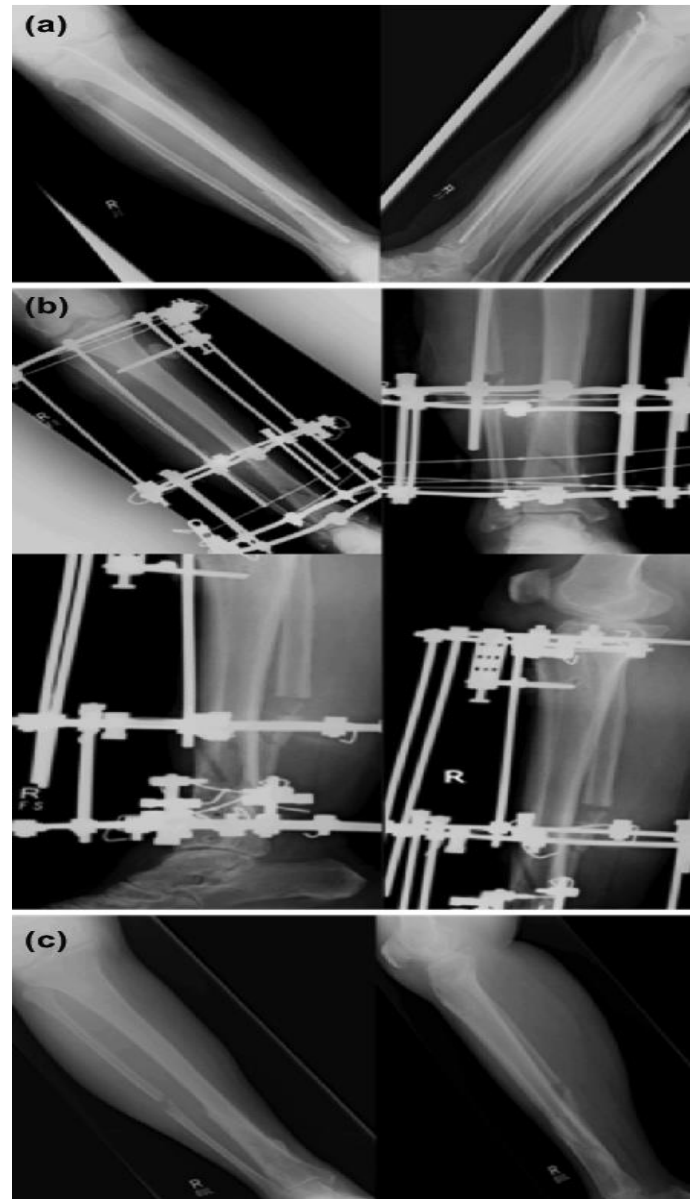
Patient 2's radiographs. (a) Anteroposterior and lateral images of the tibia before surgery demonstrate tibia nonunion. (b) Anteroposterior and side (bottom row) views following Ilizarov application. (c) Final follow-up: Anteroposterior and lateral images demonstrating bony union.
